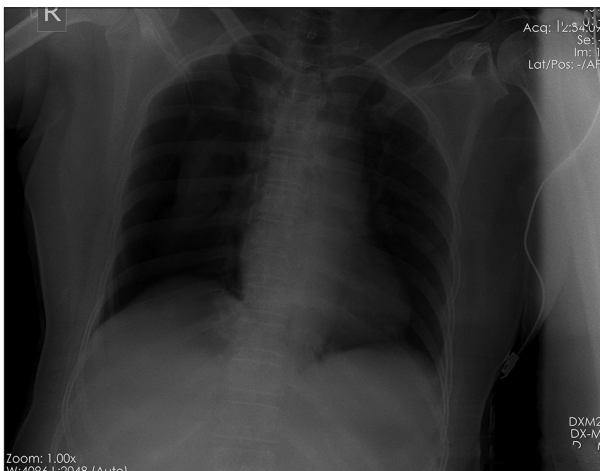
X-ray of the chest (right pneumothorax)
